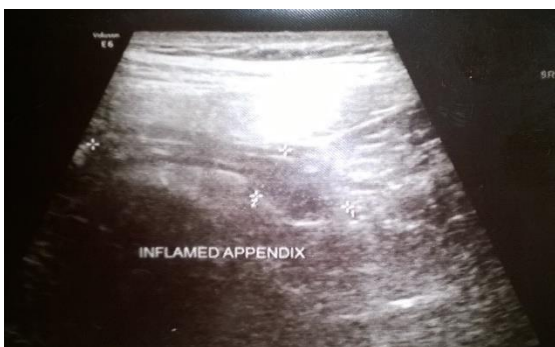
Ultrasonogram showing features suggestive of appendicitis.
